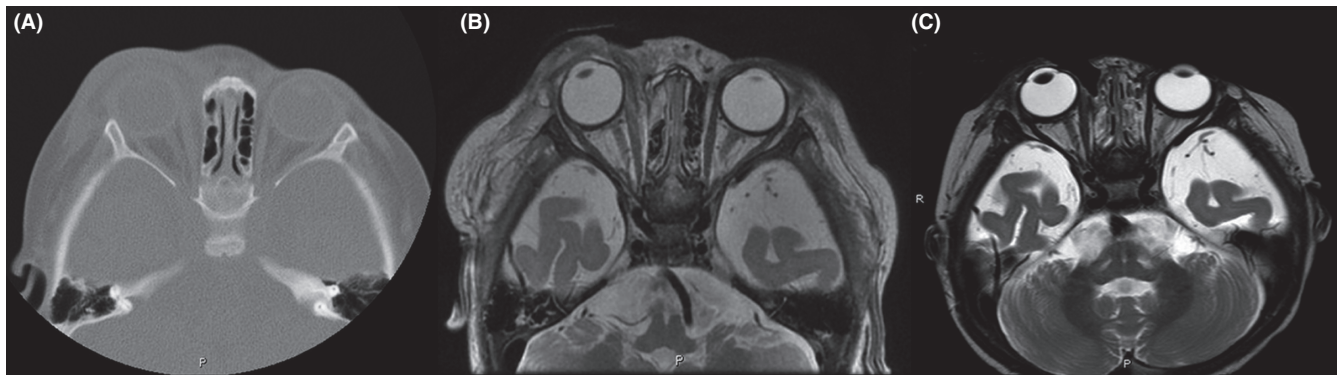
A, Noncontrast CT revealed right soft tissue swelling in the front of the orbit. The medial rectus was thickening. Orbital bone wall of media blurred. B, MRI shows significant swelling of soft tissue around the right eye, fat, and fascia. C, Five days after surgery, MRI showed improved periorbital, eyelid, and maxillofacial swelling, and low signal from the right nasal orbit
